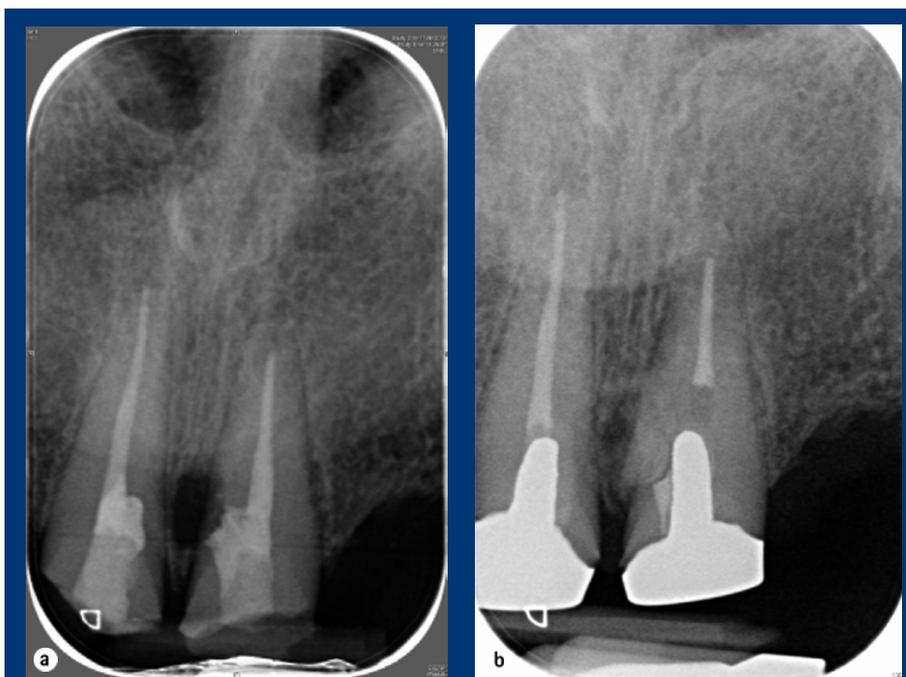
a) Localised chronic inflammation around a perforation on the mesial aspect of the 21. The lesion was surgically accessed after definitive restoration and repaired with Biodentine. b) Radiographic review at 6 months reveals evidence of bony healing and the suggestion of the formation of new periodontal ligament
